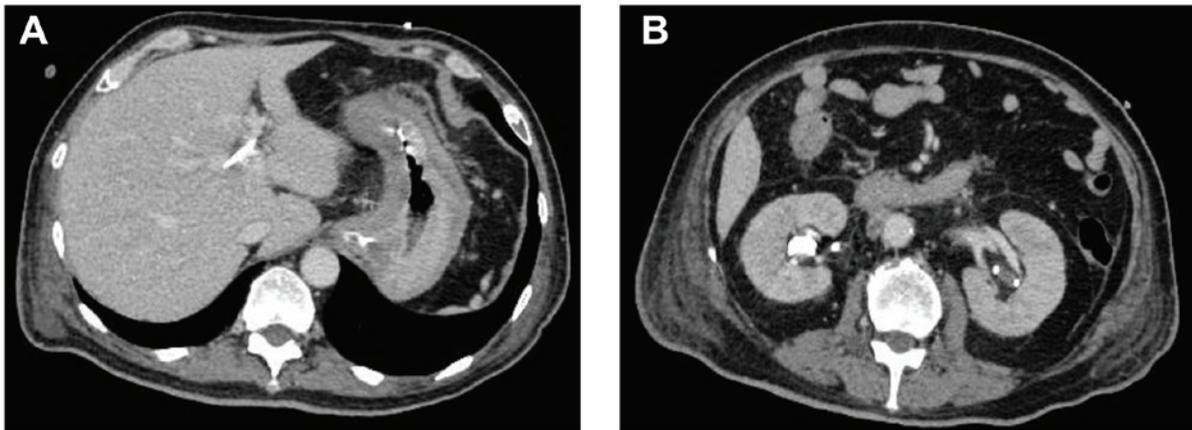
Abdominal CT scan post-chemotherapy. (A) CT scan image revealed the disappearance of ascites and improvement of hydronephrosis (B).
